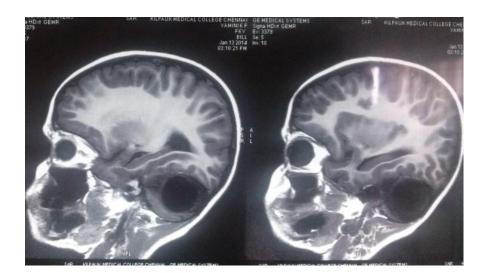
T1 WEIGHTED MRI SHOWING CYSTIC LESION IN THE CEREBELLUM
